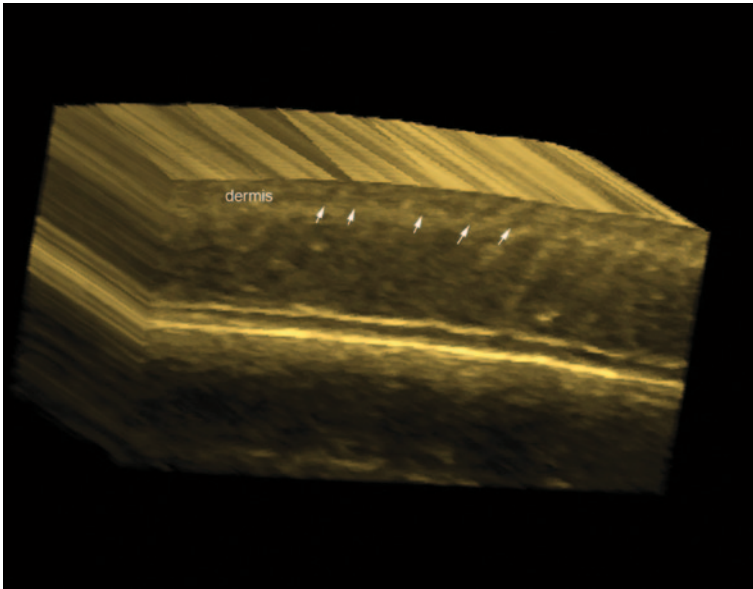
Sonographic anatomy of the normal hair follicles (*arrows*) of the scalp
